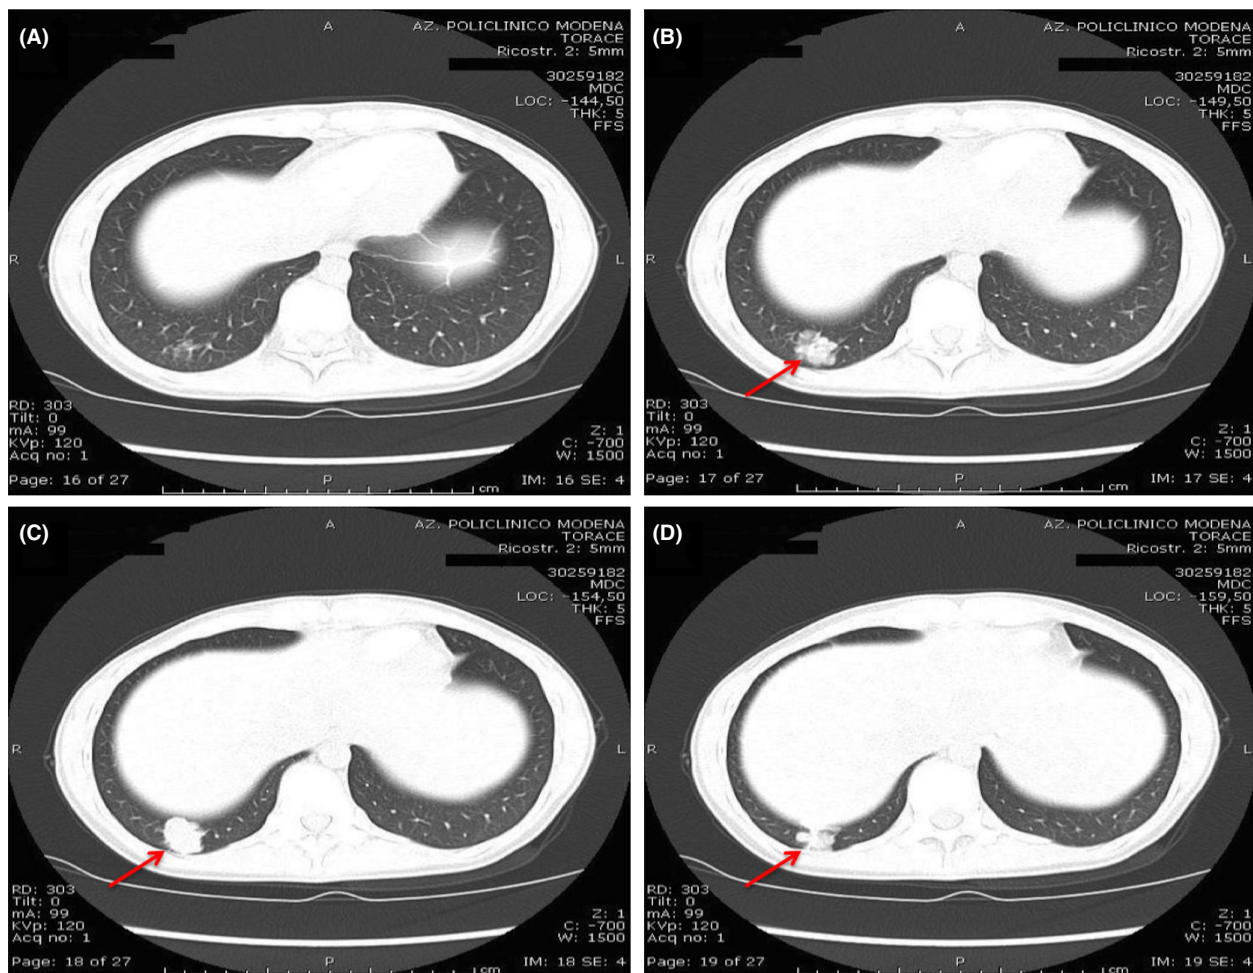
(A–D) High-resolution CT scan showing 2.5 cm diameter lesion with irregular borders in keeping with benign lesion.
